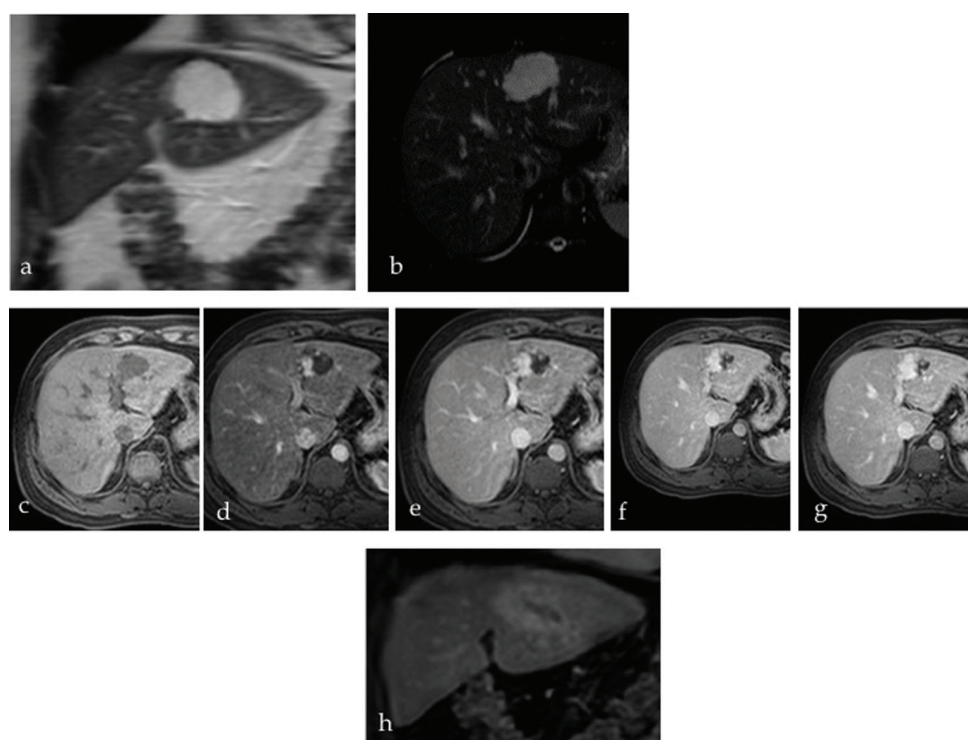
Haemangioma on magnetic resonance imaging. a and b. T2W images show an intensely bright well-defined lesion. c–h. Pre- and dynamic post-contrast images at different phases show nodular peripheral enhancement with centripetal filling.
